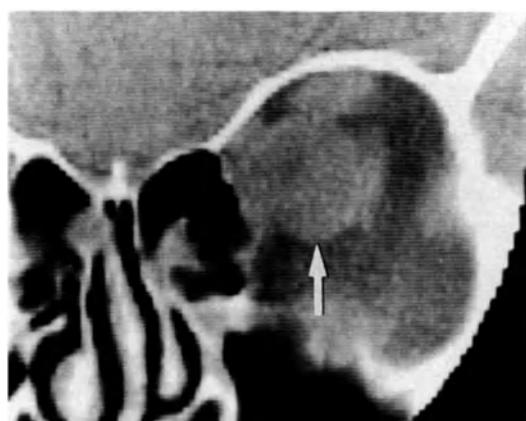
Coronal CT scan. Cavernous hemangioma. Typical rounded, well-defined mass within the muscle cone (arrow).
